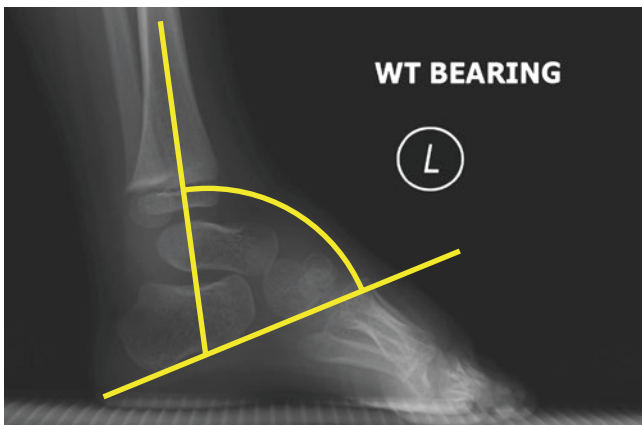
Radiograph of the tibio-calcaneal lateral weight bearing angle
